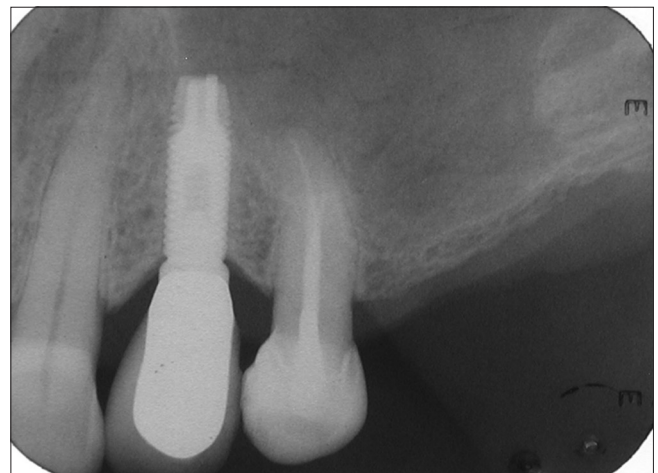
Ten years control - Periapical radiograph
